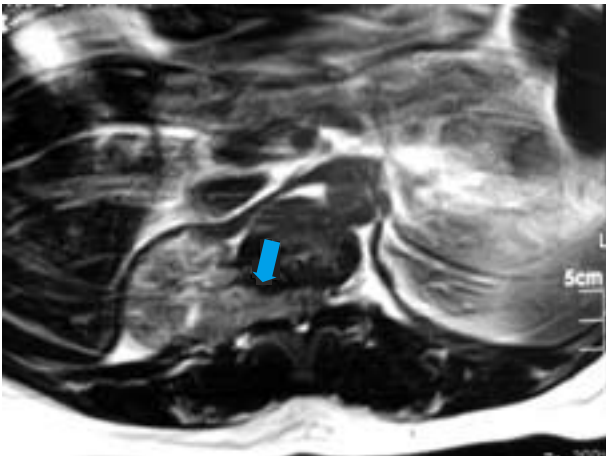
Chest MRI shows a tumor invading the spinal canal (arrow) via the intervertebral foramen (Eden type III dumbbell tumor).
